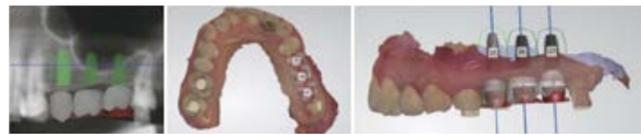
Data (CT data and intraoral scan data) and mock surgery through digital imaging device
